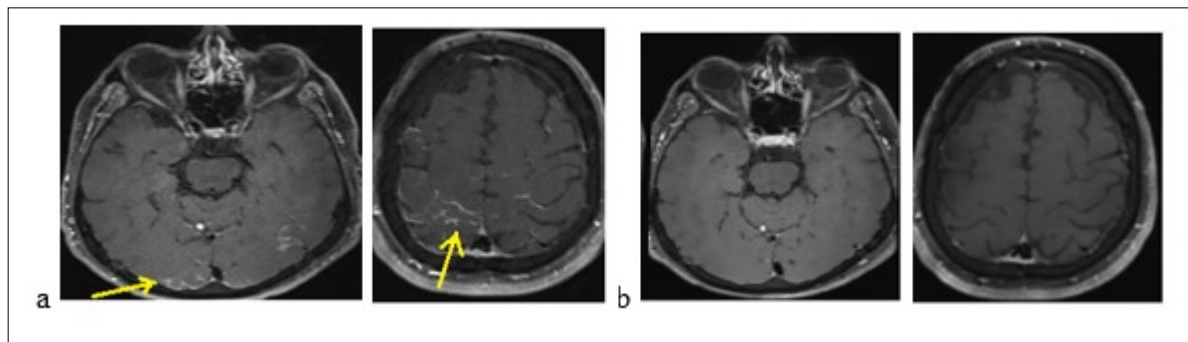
Brain MRI displaying occipital cortical hypersignals in Flair sequences (a) and decrease of lesions (b)
